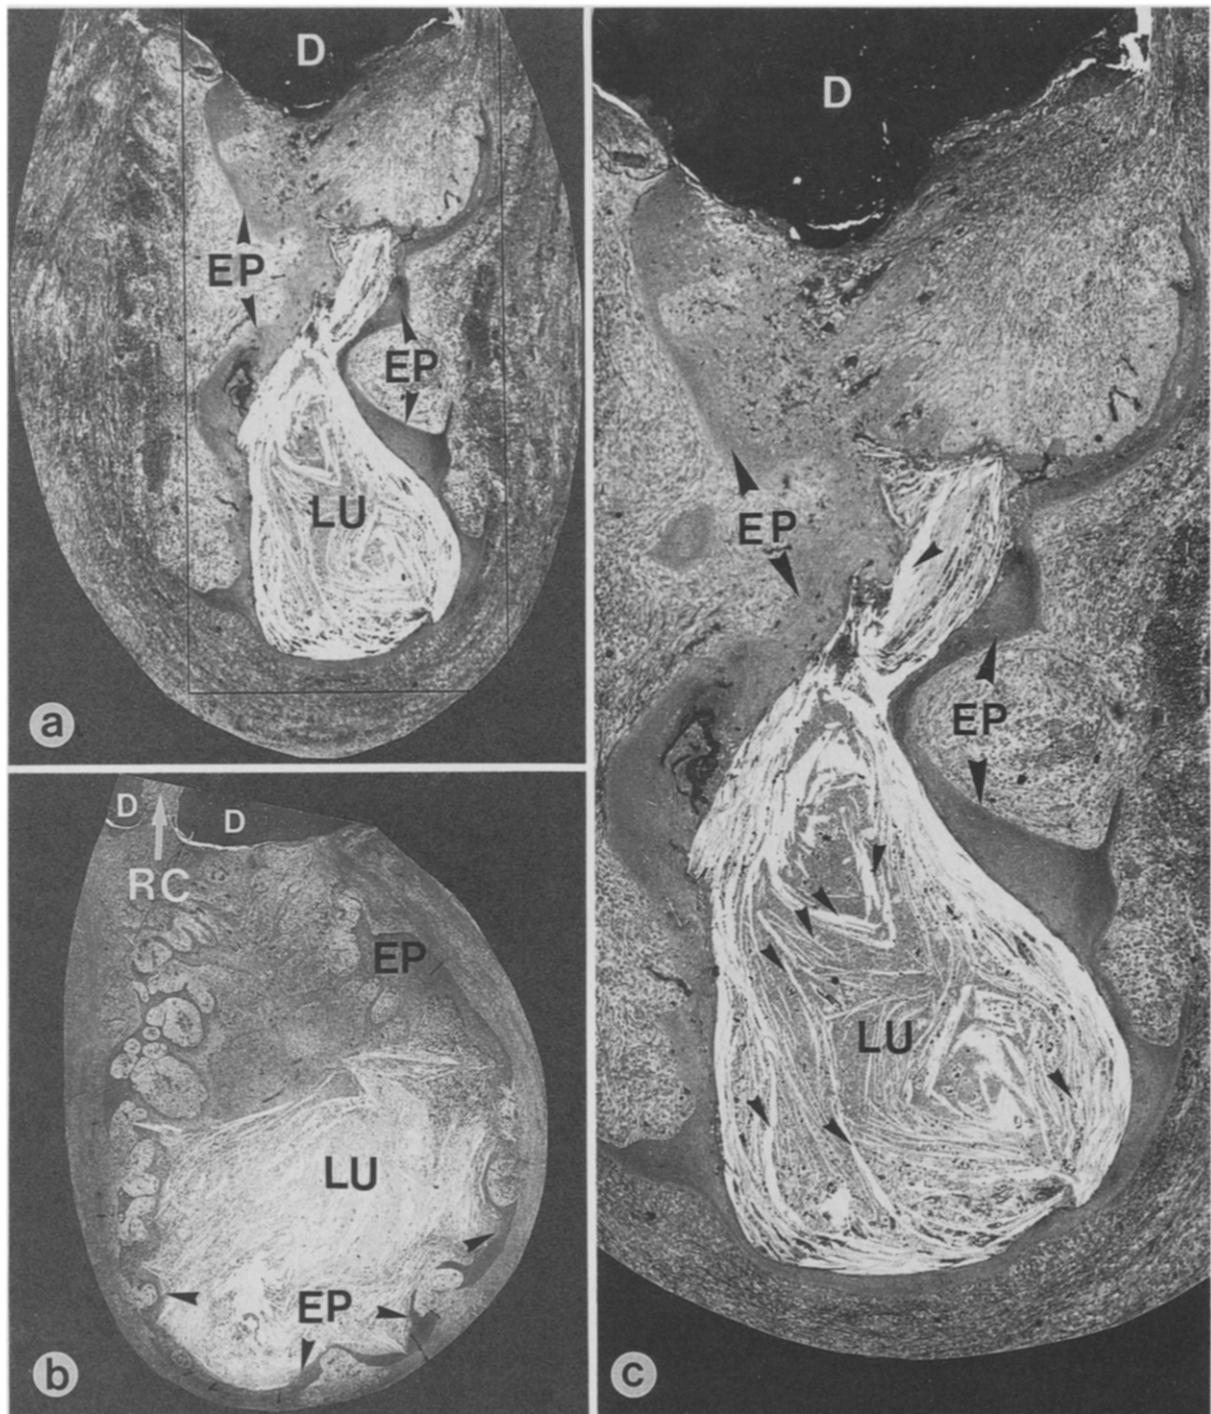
A and B, Periapical true cysts. Cyst lumina (*LU*) are completely enclosed in stratified squamous epithelium (*EP*). Note absence of any communication of the cyst lumen with the root canal (*RC* in B). Demarcated area in A is magnified in C. *Arrowheads* in C indicate cholesterol clefts. (Original magnifications: A $\times 30$, B $\times 17$, C $\times 60$.)
